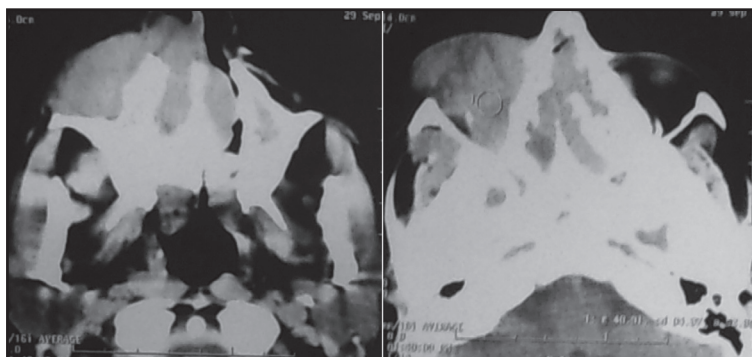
Heterogenous mass in both nasal cavities, maxillary sinuses and the right orbit causing proptosis (non-contrast CT scan).
